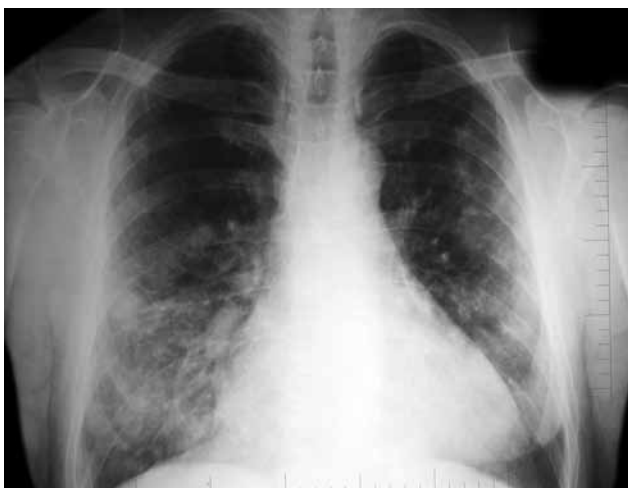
The chest X-ray at admission.
